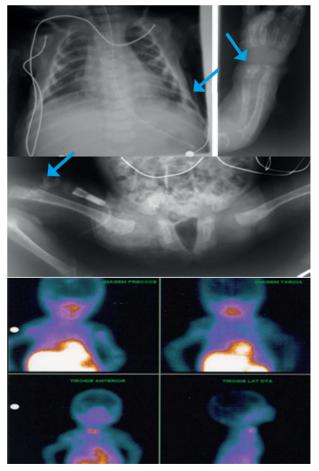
A. Radiographs showing osteopenia and green stick fractures (arrows). B. Scintigraphy of the parathyroid glands (99mTc-sestamibi) and of the thyroid gland (99mTc): Normal size and function of both parathyroids and thyroid.
